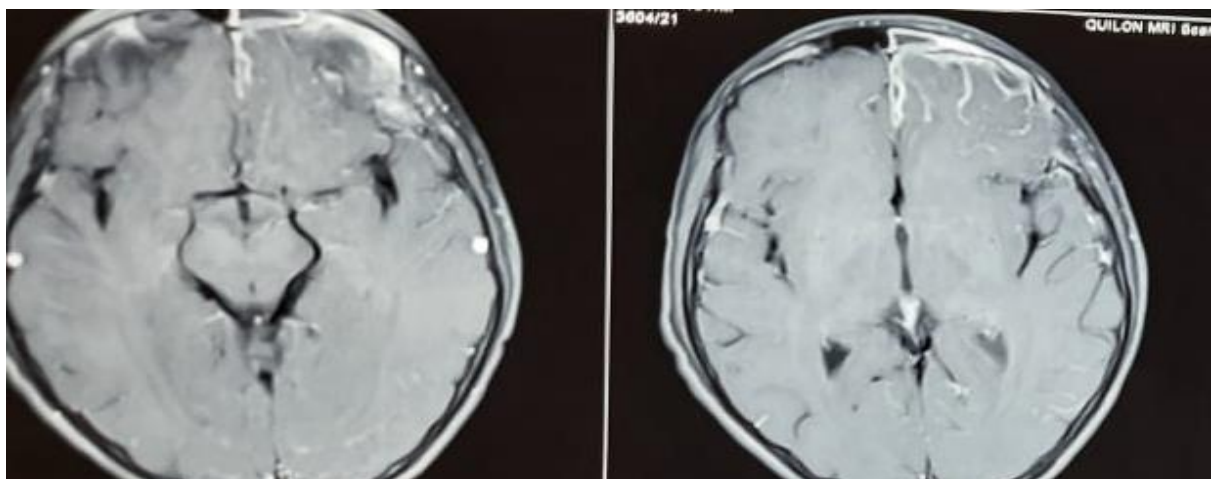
MRI showing empyema involving left fronto - parietal subdura and interhemispheric fissure.
